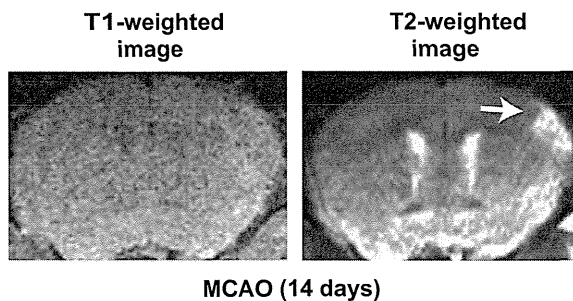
MRI experiments 14 days after MCAO. Left shows T1-weighted image. Right shows T2-weighted image. White arrow indicates the high intensity area in the T2-weighted image.
